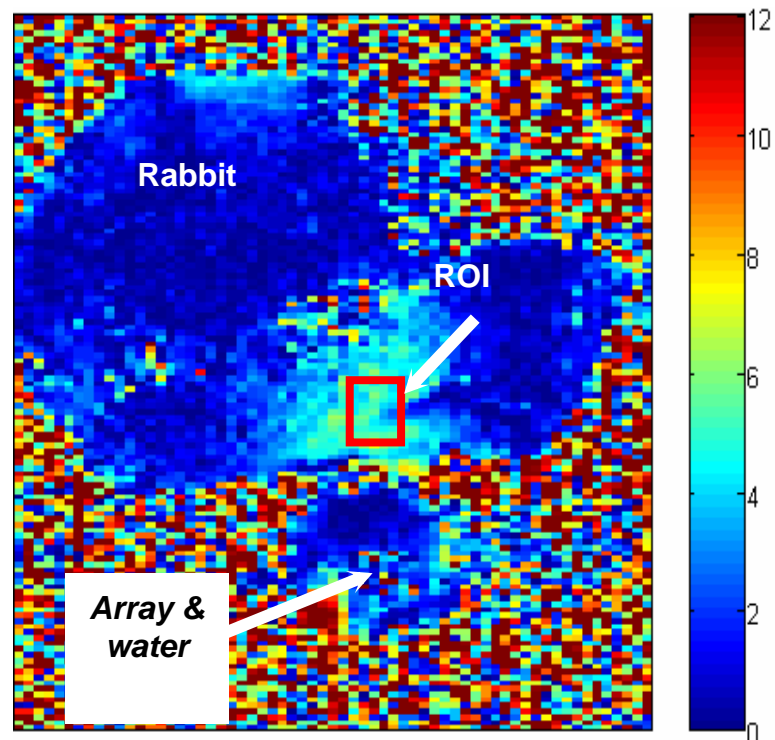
The temperature map (temperature change indicated by the color bar on the right of the figure in °C) of the axial view of the MRI-guided *in vivo* ultrasound hyperthermia experiments setup.
